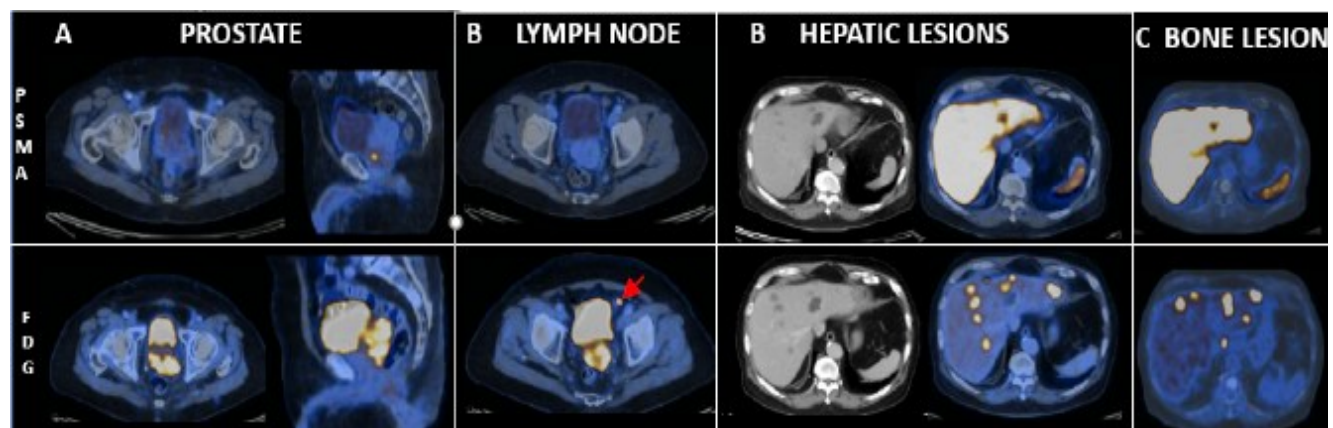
Comparison of fused F-18 PSMA PET/CT and F-18 FDG PET/CT images with a 1-week interval .
